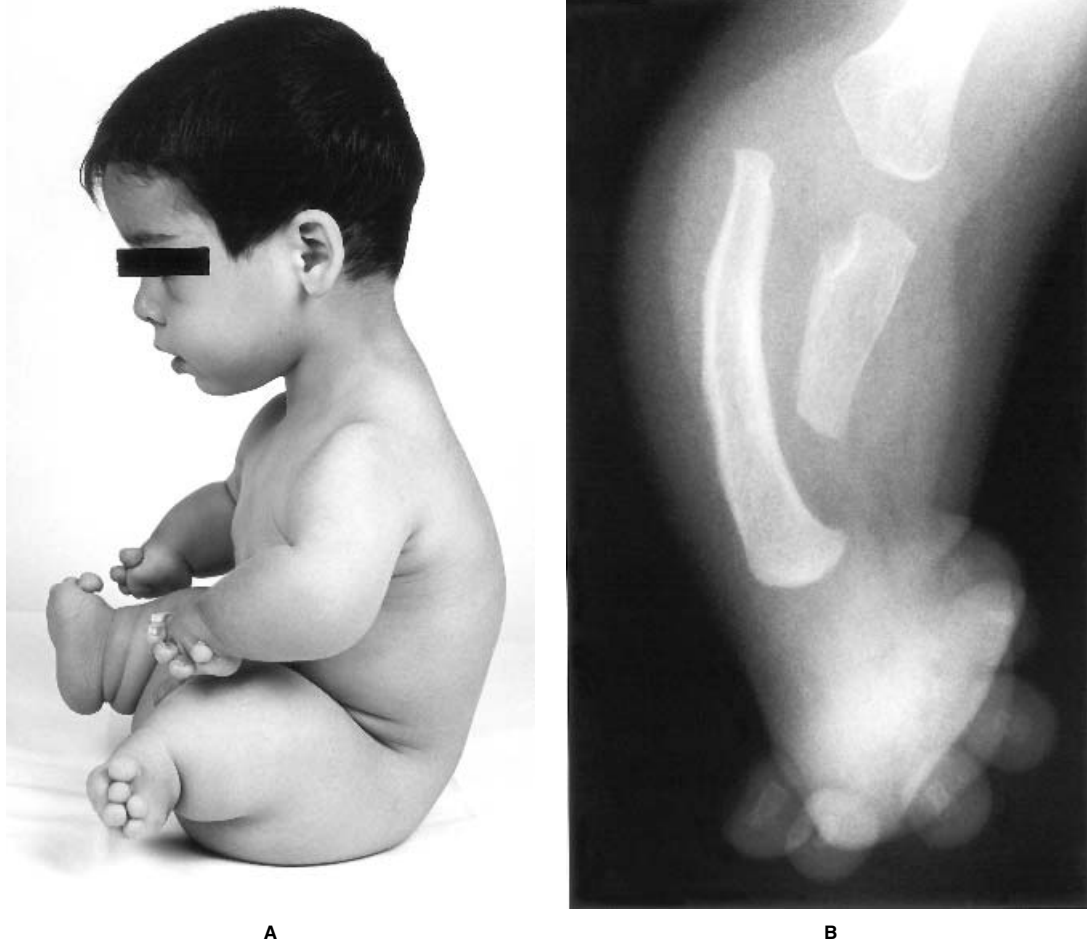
Acromesomelic dysplasia Grebe type. (A) 4-year-old boy with Grebe dysplasia showing severe mesomelic limb reduction. Both parents show a mild form of brachydactyly type C (radiograph of father's hand is shown in Fig. 13). Note very short fingers and toes. The legs are shorter than the arms. (B) Radiograph of the upper limb of patient in (A) showing severely deformed and shortened radius and ulna with rudimentary carpal bones and fingers. (Courtesy of B. Zabel, Mainz.)
